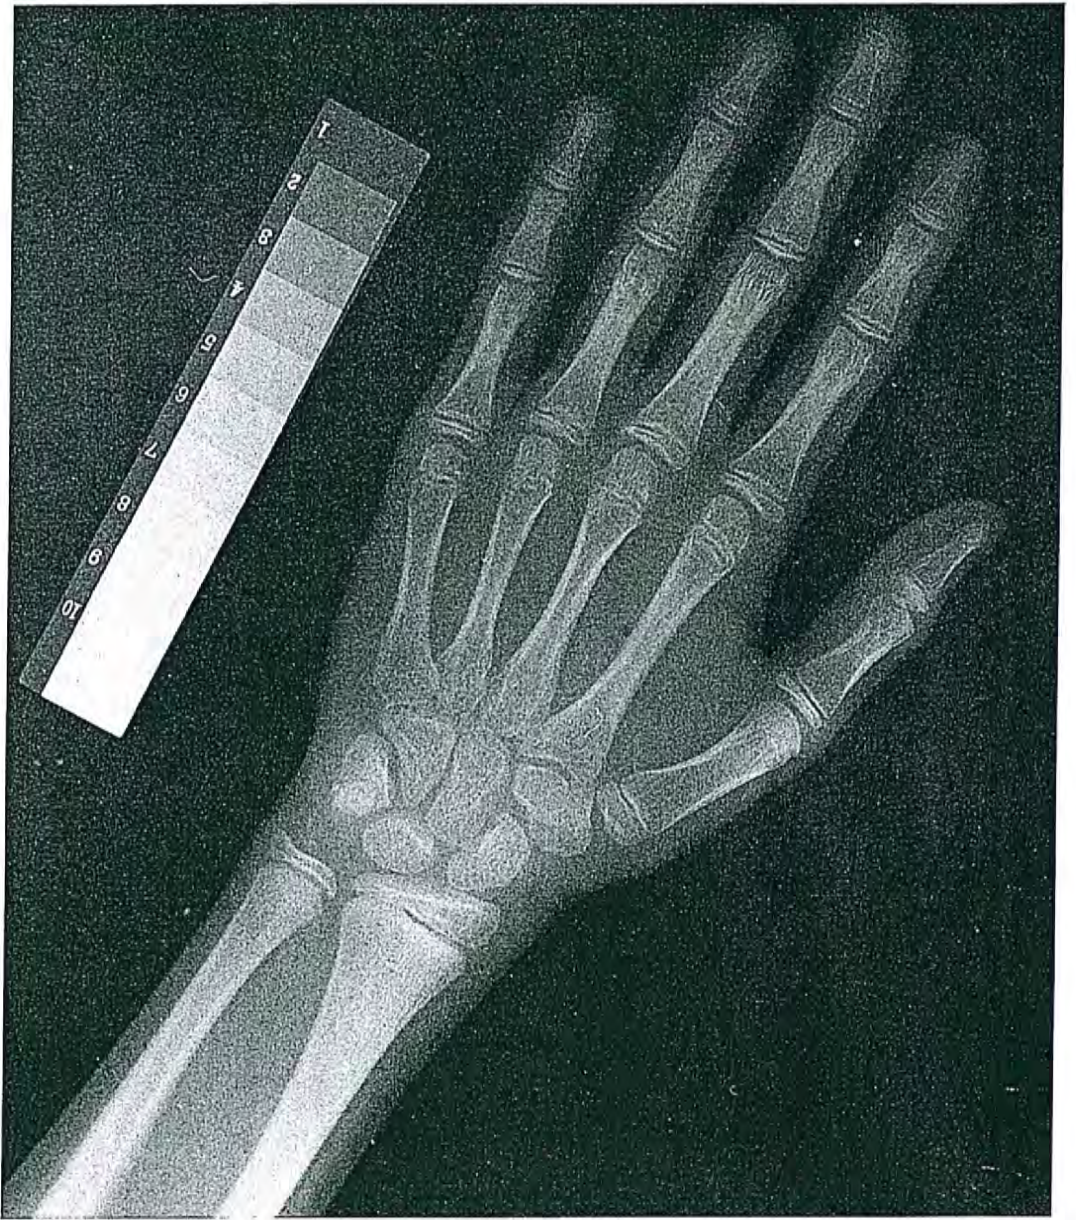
Wrist x-ray film of a girl with a chronologic age of 10 years 6 months and a skeletal age of 9 years 9 months.
